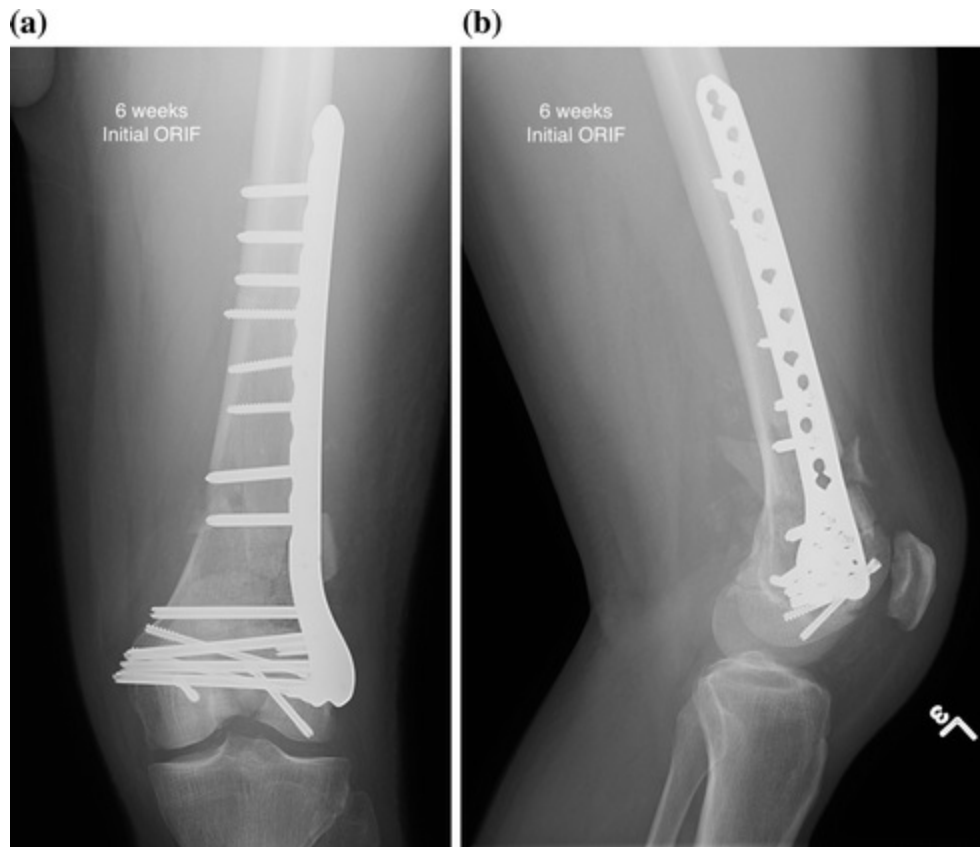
a Anteroposterior and b lateral left knee radiographs at 6 weeks after open reduction internal fixation. The fracture appears well reduced and restoration of the anatomical axis
